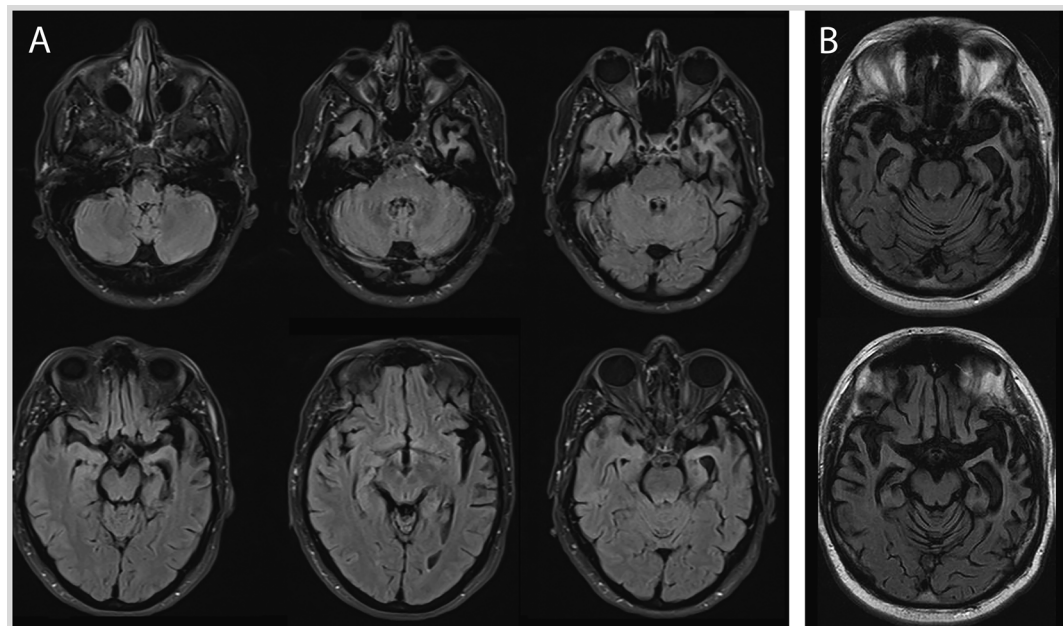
Imaging of the patient in Case 5-2. *A*, Axial fluid-attenuated inversion recovery (FLAIR) MRI demonstrating left temporal pole atrophy suggestive of semantic variant primary progressive aphasia. *B*, With disease progression, severe atrophy is observed in the left temporal pole as well as significant atrophy in the right temporal pole on axial FLAIR MRI.
